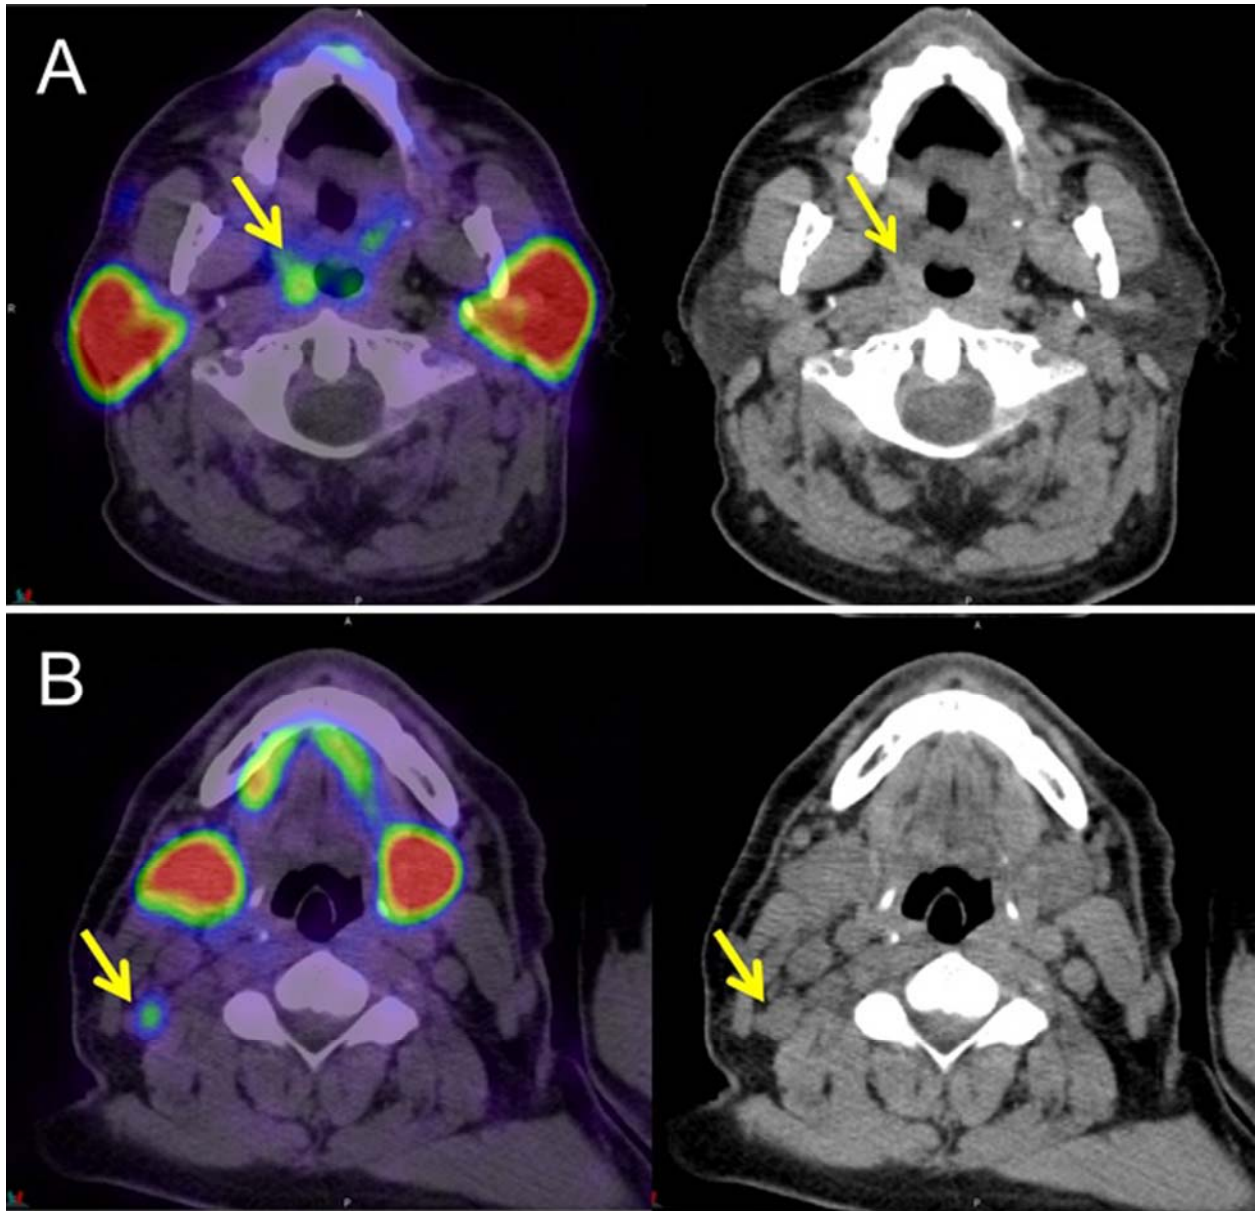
Incidental finding on PSMA PET/CT of focal uptake (SUVmax 5.3) in the right oropharynx (A) and ipsilateral mildly enlarged level II lymph nodes (SUVmax 3.6) (B). Biopsy demonstrated squamous cell carcinoma.
